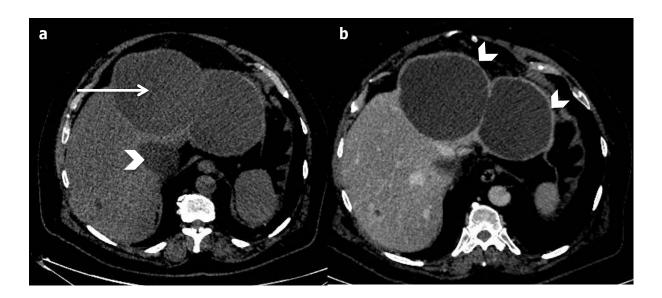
Infected simple hepatic cysts in a 77-year-old male patient with autosomal dominant polycystic liver disease. (a) Axial non-enhanced computed tomography shows two tensioned cysts (arrow) slightly more attenuating than non-infected cysts (arrowhead); (b) with thick enhanced wall at portal venous-phase (arrowhead).
